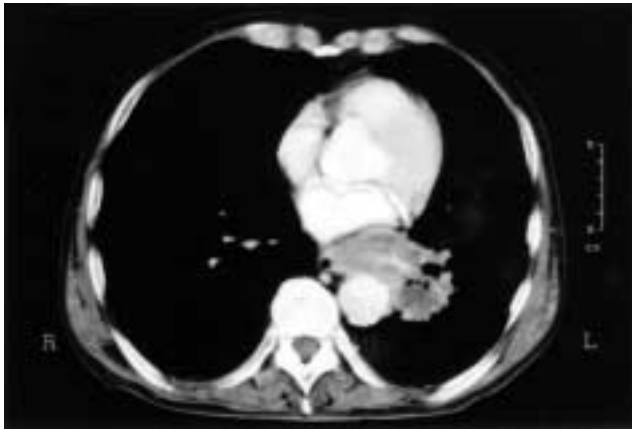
Chest CT scan (Case 1).
